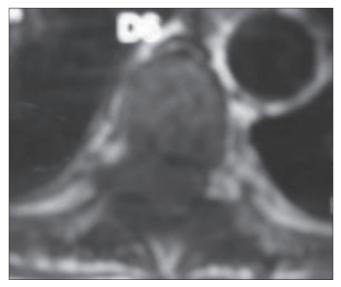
Axial T1-weighted image shows an epidural soft tissue mass in the right side of the dorsal spinal canal at D6 vertebral level, causing thecal sac compression
